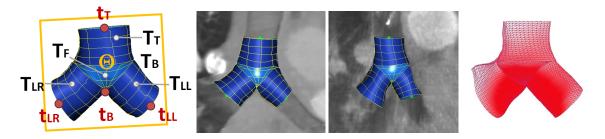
The trachea bifurcation model. Left: Model showing the bounding box Θ , anatomical landmarks: trachea airway bifurcation point t_B , trachea lower-left airway branching point t_{LL} , trachea lower-right airway branching point t_{LR} , trachea upper center airway point t_T and surfaces: trachea upper center airway model T_T , trachea lower-left airway model T_{LL} and trachea lower-right T_{LR} airway model, trachea bifurcation face T_F and back T_B . Trachea bifurcation model shown in CT and 3D C-arm CT (center). The right image is showing the trachea bifurcation model with weights assigned to each vertex for preoperative to intra-operative mapping A: white - low significance, red - high significance.
